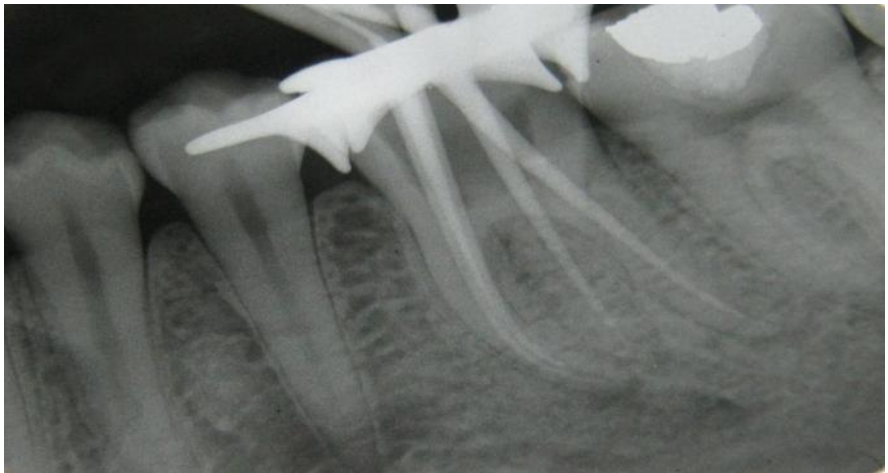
(b) Master cone selection radiograph
